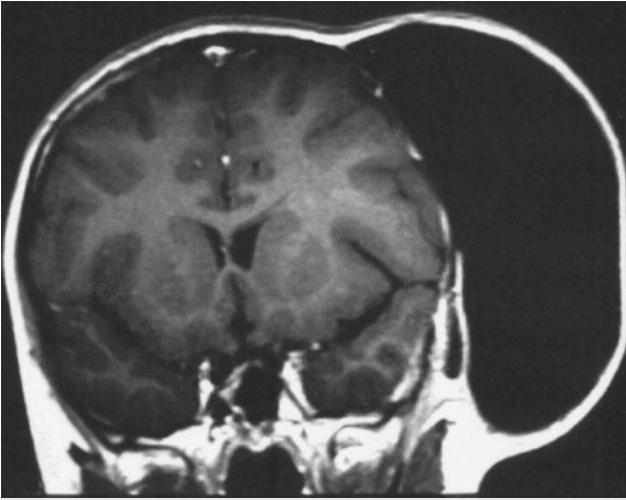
T1-weighted coronal magnetic resonance image of a 12-year-old boy who underwent a craniotomy for evacuation of a subdural empyema. The bone flap was left out, and the dura opened as a result of massive brain swelling. This acquired meningocele contained 510 mL of cerebrospinal fluid and subsided with replacement of the bone flap.
